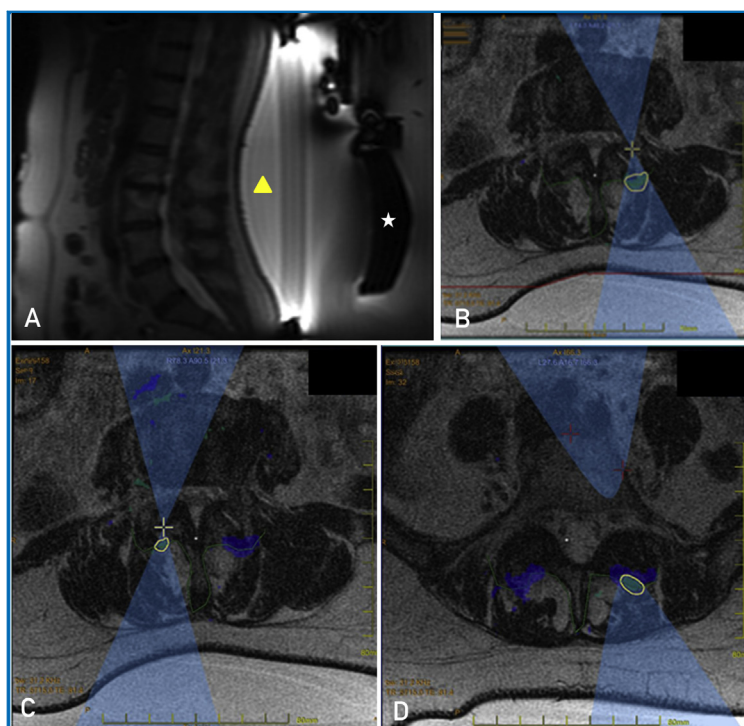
A, Sagittal T2-weighted scout magnetic resonance (MR) image obtained prior to MR imaging–guided focused ultrasound. The patient is lying supine on the treatment table, with the ultrasound transducer (star) directly below the lumbar spine. Water is interposed between the transducer and the patient's skin in order to prevent skin burns (arrowhead). B-D, Selected axial MR images showing ablation targets (yellow ovals) that were placed along the posterior facet joint capsule by the proceduralist. The light blue shaded areas demonstrate nonablated tissue along the path of the ultrasound beam; this path can be manually adjusted to avoid structures such as the spinous process that would block the ultrasound waves from reaching the desired target. Dark blue color is generated by the treatment software and indicates previously treated tissue along the posterior facet joint capsules.
